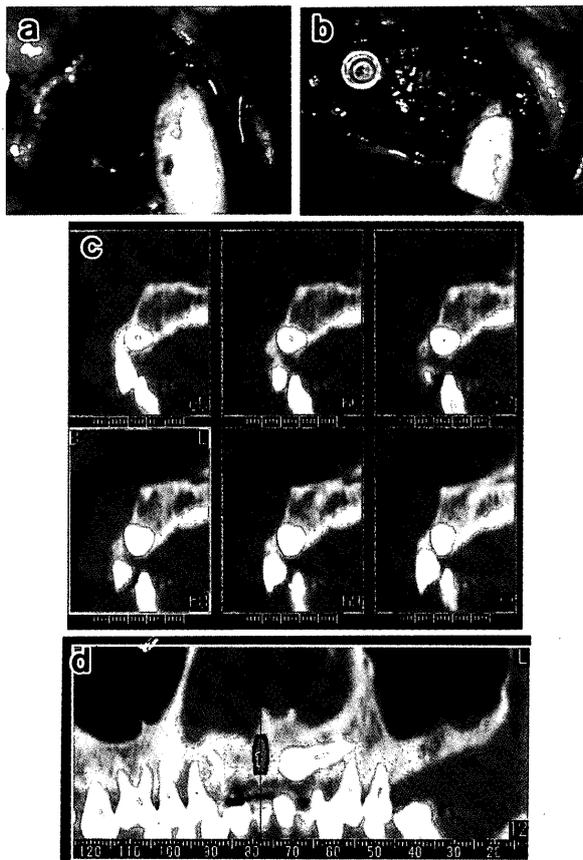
Photographs before operation (a) and 6 months after operation (b), CT image (c) and panoramic view (d) of the defect from Patient 2.
